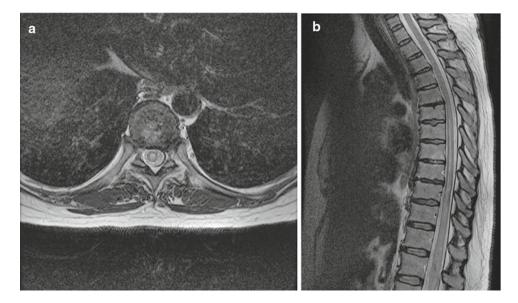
Established cord infarct with central T2 hyperintensity. (a) Axial T2 MRI. (b) Sagittal T2 MRI
